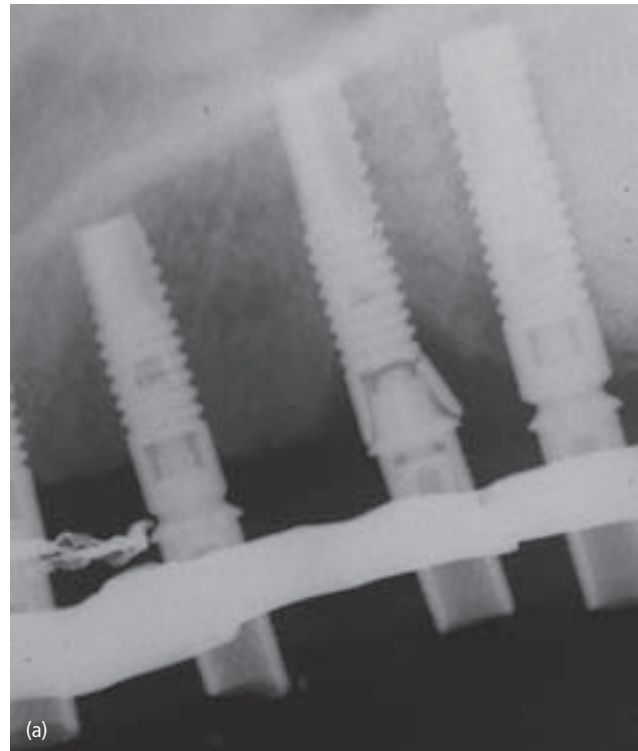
(a) Radiograph of a fractured implant. (b) Clinical presentation of the fractured implant seen in (a).
